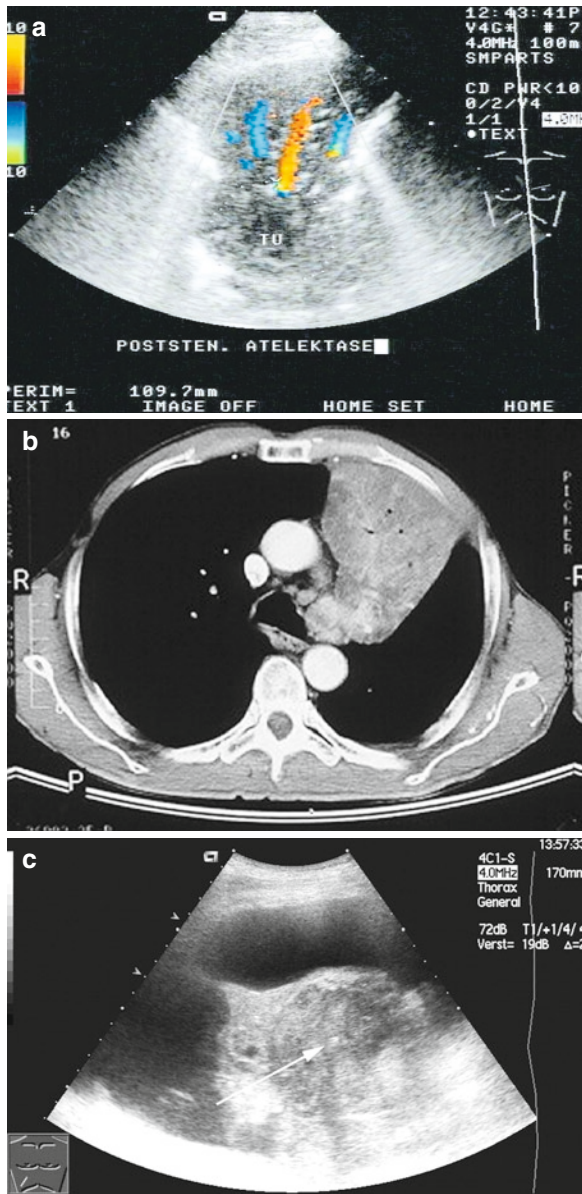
A 50-year-old man with retrosternal pain that initially raised suspicion of coronary heart disease. Sonography showed a large tumor in the upper lobe in left parasternal location, penetrating the mediastinum and fully destroying the bronchial branches. In the tumor there is a calcification accompanied by obliteration of echoes in the dorsal aspect (*arrow*). Sonographic biopsy indicated poorly differentiated adenocarcinoma with tumor cell complexes in lymphatic recesses
